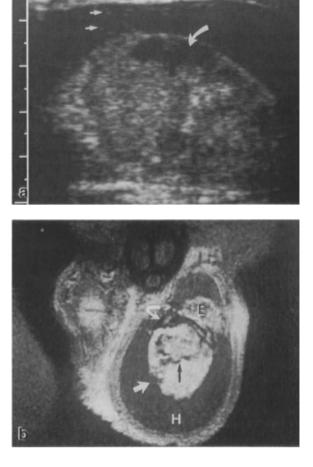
a Subacute testicular trauma is shown on a longitudinal sonogram. Anechoic fluid with scattered internal echoes (arrows) is noted in the left scrotal sac surrounding the testis, indicating hematocele. Heterogeneous internal architecture and a subtunical anechoic space (curved arrow) confirm intratesticular hematoma. b A T2-weighted coronal scan of the scrotum depicts the intratesticular hematoma (black arrow), a tunical defect (thick white arrow) that was not suspected on the sonogram, subtunical hemorrhage (curved arrow), enlarged swollen epididymis (E), and a hematocele (H). (BAKER et al. 1987)
